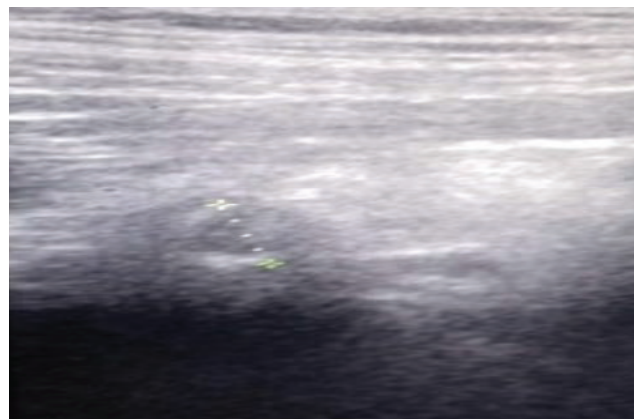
Ultrasound image showing appendix with a diameter of 1.2 cm, with thickened walls and peri-appendiceal fat stranding.
